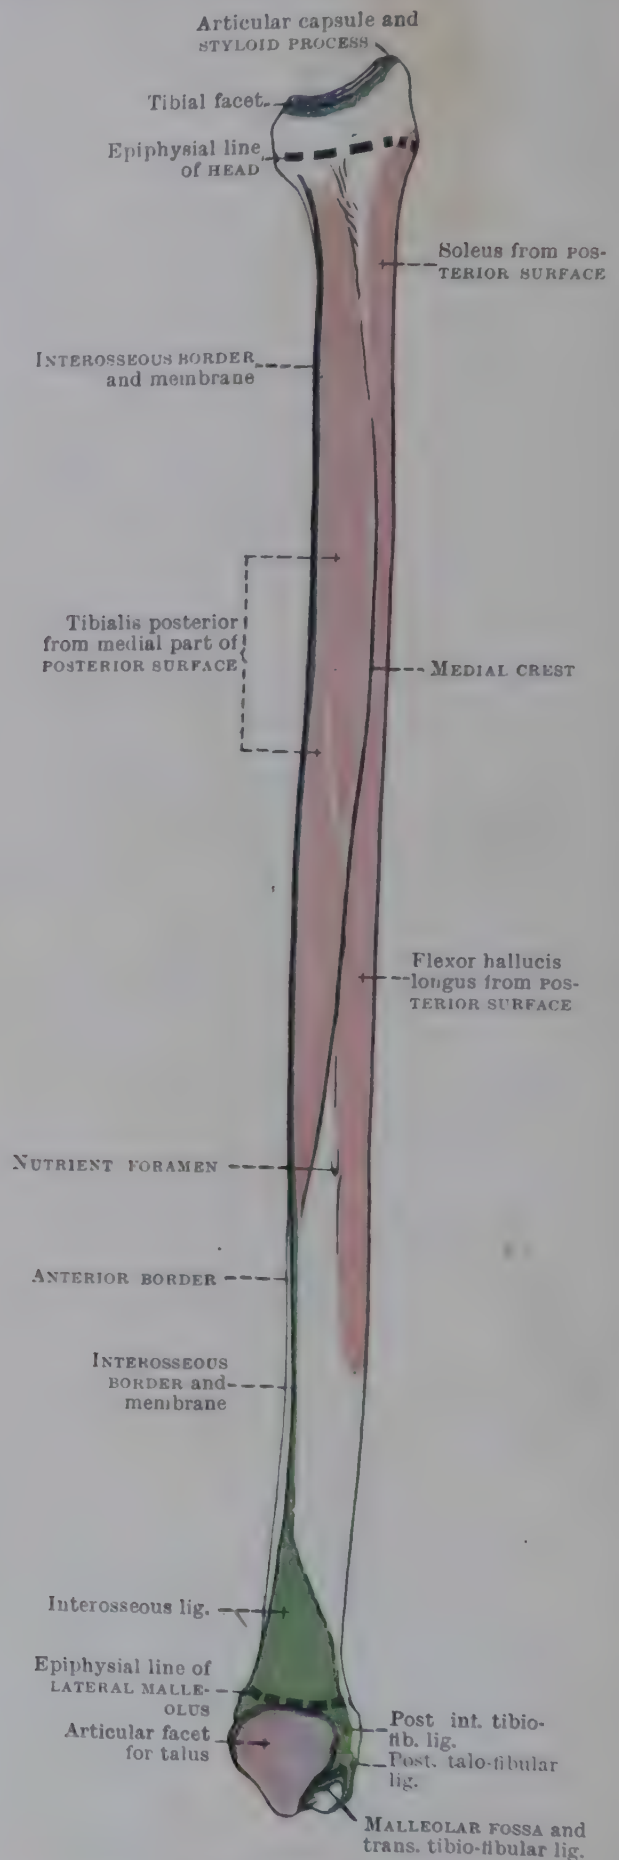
MEDIAL ASPECT OF RIGHT FIBULA.
